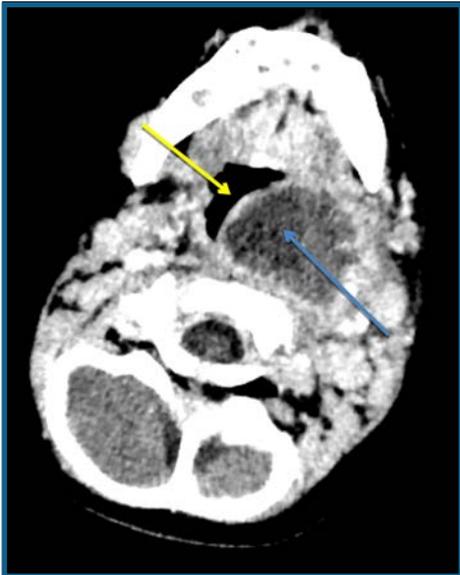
Contrast enhanced CT demonstrating a large left parapharyngeal abscess (PPA) measuring 3.5 cm x 3.0 cm at the greatest dimension and 3.5 cm vertical with irregular contours and a thin enhancing wall (blue arrow). Mass effect with displacement of the hypopharynx and the epiglottis (yellow arrow).
